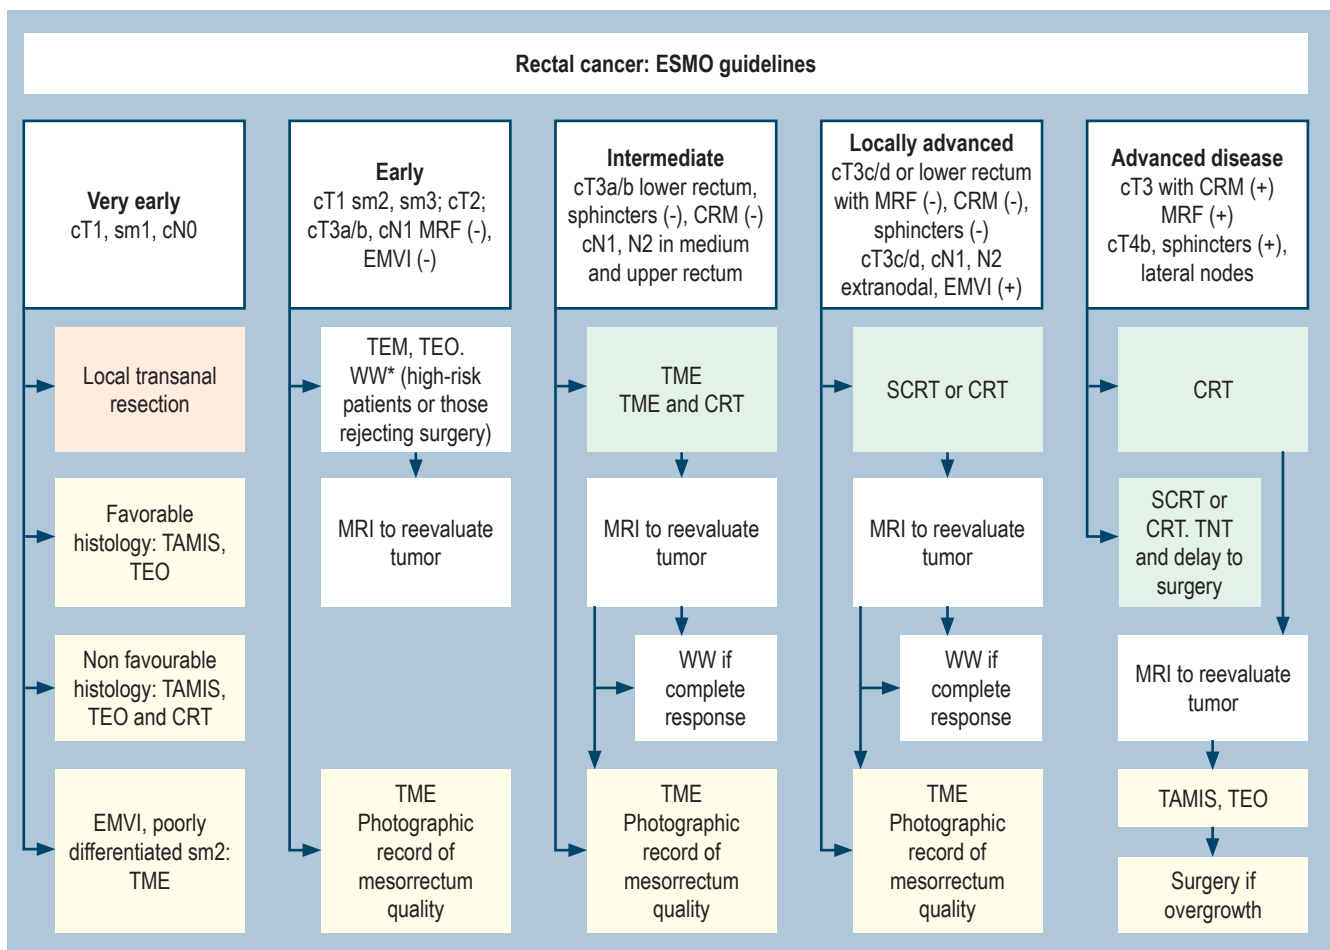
Recommendations for rectal cancer management according to ESMO. cN: Clinical nodal status; CRM: Circumferential resection margin; cT: Primary clinical tumor size; EMVI: Extramural vascular invasion; MRF: Mesorectal fascia; CRT: Chemoradiotherapy; MRI: magnetic resonance imaging; sm: submucosa; TAMIS: Transanal minimally invasive surgery; TEM: Transanal endoscopic microsurgery; TME: Total mesorectal excision; TEO: Transanal endoscopic operation; TNT: Total neoadjuvant therapy; WW: Watch and wait. Source: ESMO rectal cancer guidelines.
